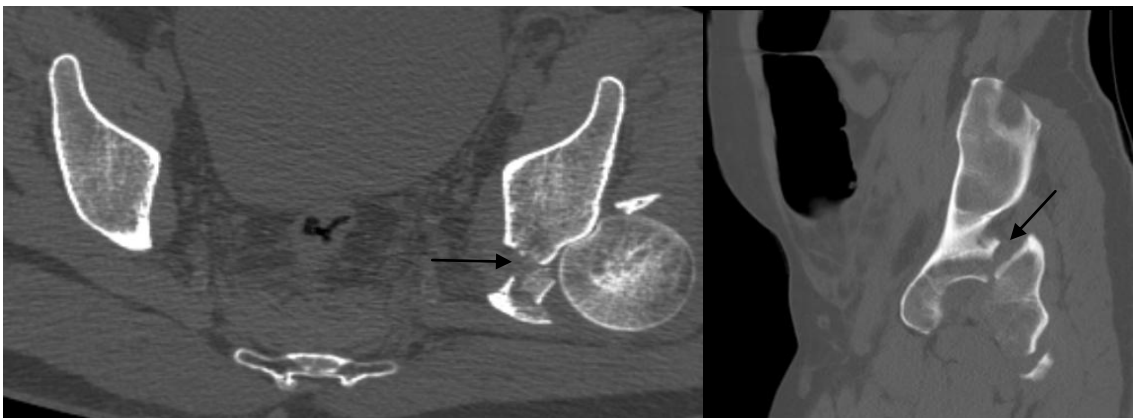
Left T-shaped acetabular fracture. Axial (A and C),and sagittal(B) Pelvic computed tomography (CT) scan of a 28 years old male shows the vertically oriented transverse fracture (small arrow) of the left acetabulum with fracture line extension to the ipsilateral inferior pubic ramus(arrow).
